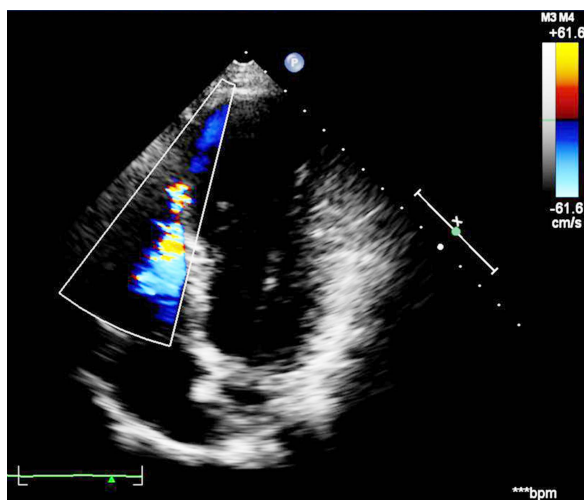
Apical four-chamber view colour Doppler imaging showing apical septal defect with left to right shunt.
